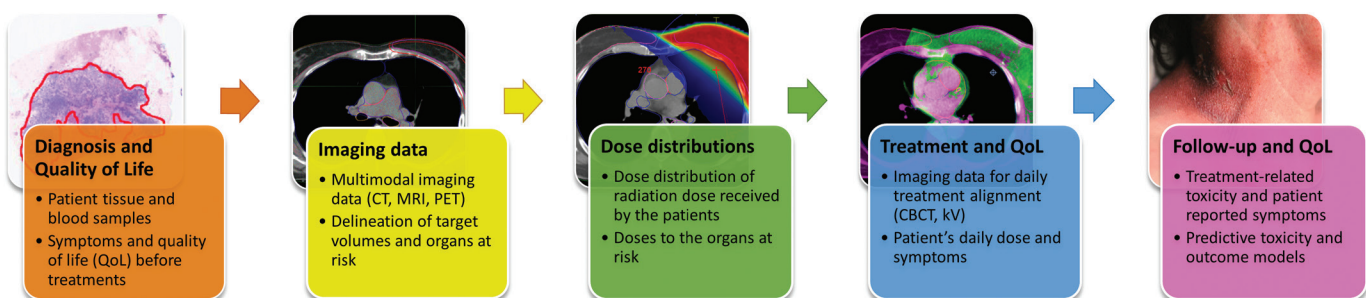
Multimodal data framework of KaSARi, linking baseline clinical variables, imaging and dose data, treatment monitoring, and longitudinal toxicity and quality of life (QoL) outcomes for predictive modeling. CT: computed tomography; MRI: magnetic resonance imaging; PET: positron emission tomography; CBCT: cone-beam computed tomography; kV: kilovolt imaging.
